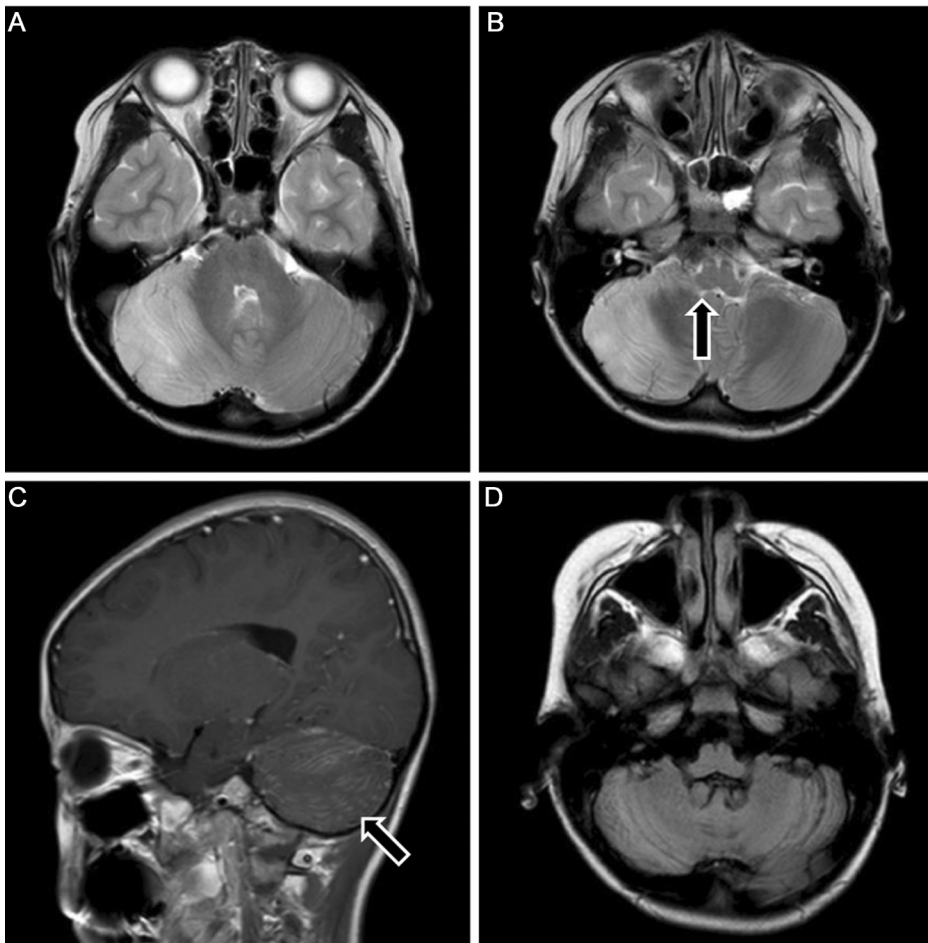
Initial and follow-up brain MRI findings. Axial T_2 -weighted MRI shows diffuse high signal intensity in the cerebellar hemispheres, much more prominently on the right side (A), and mild compression of the right side in the brainstem (arrow) (B). Sagittal gadolinium-enhanced T_1 -weighted MRI shows pial enhancement along the cerebellar folia (arrow) (C). In two-month follow-up brain MRI, axial fluid attenuated inversion recovery imaging shows diffuse atrophy of both cerebellar hemispheres and remaining subtle signal changes (D).
